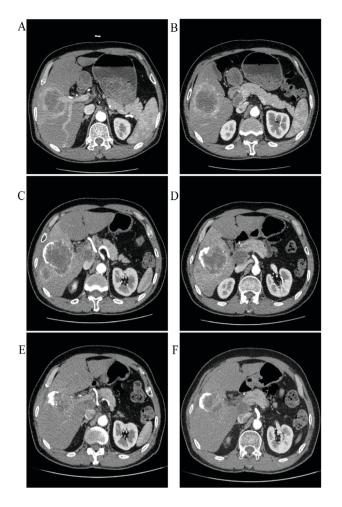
Abdominal computed tomography (CT) imaging of metastatic live lesion lymph node lesions before and after AZD9291 treatment. (A and B) At diagnosis of the metastases after administrating icotinib for 14 months (Dec 23, 2014); (C and D)After 2 months of transcatheter arterial chemoembolization, revealing disease progression (Mar 27, 2015); (E and F)After 20 days of combination treatment of icotinib and AZD9291, revealing a dramatic response(Apr 3, 2015).
